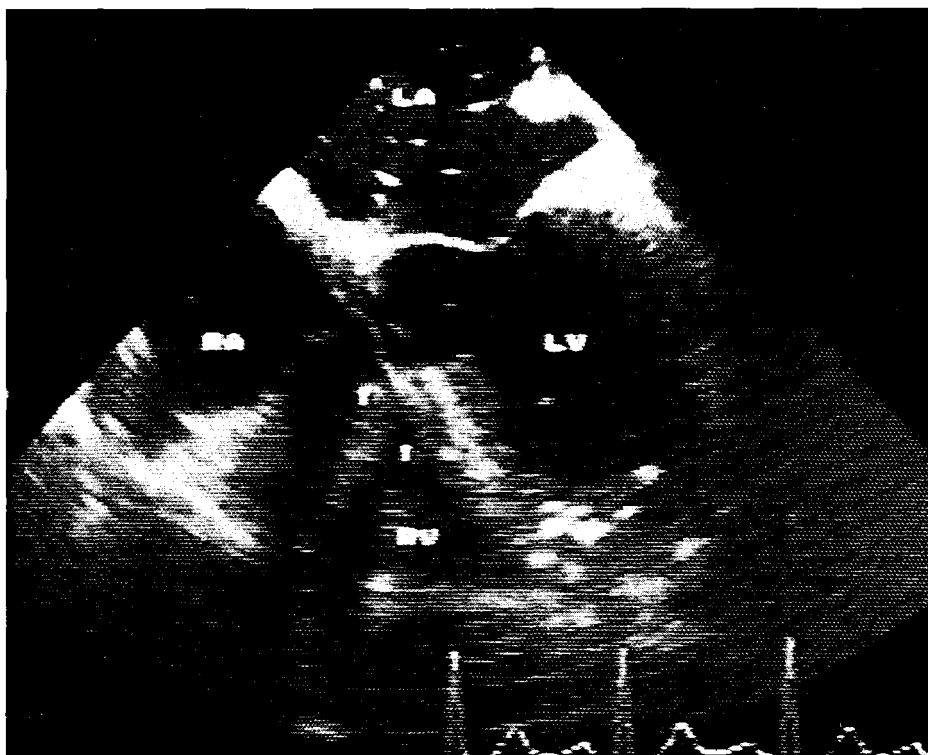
Transesophageal study immediate after patch closure of a ventricular septal defect in a patient with tetralogy of Fallot. Note the large areas of ultrasound masking distal to the patch, which preclude the meaningful acquisition of color Doppler information. (abbreviations see figures 1,2)
